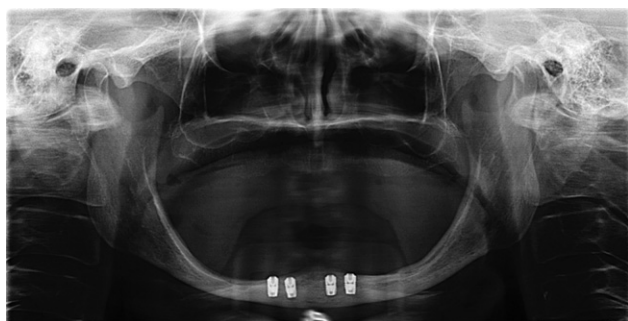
Panoramic radiograph of the same patient as in Figure 1 after insertion of four 6-mm implants in the interforaminal region of the mandible.
